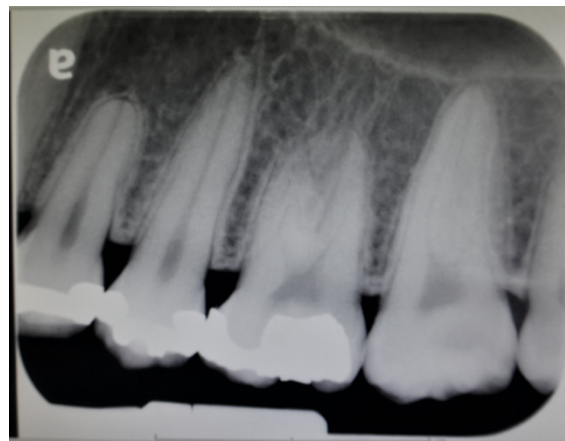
Radiographic image, left upper first molar. Incomplete roots are evident, with no apparent pathological apical lesion.
